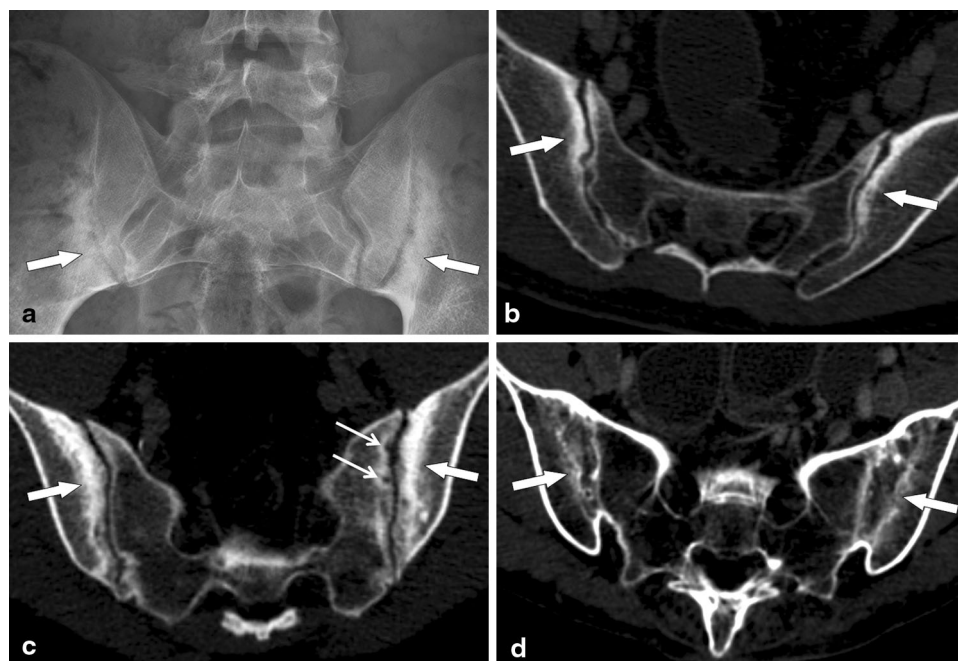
a–d Radiographic and computed tomography (CT) scoring of sacroiliitis by means of the New York modified criteria in four patients with primary ankylosing spondylitis. a Anteroposterior radiograph shows bilateral grade 3 sacroiliitis with diffuse subchondral sclerosis involving the iliac (antero-inferior) portion of both sacroiliac joints and widening of the joint space, which is more evident on the left side (*arrows*). b Axial CT scan shows bilateral
